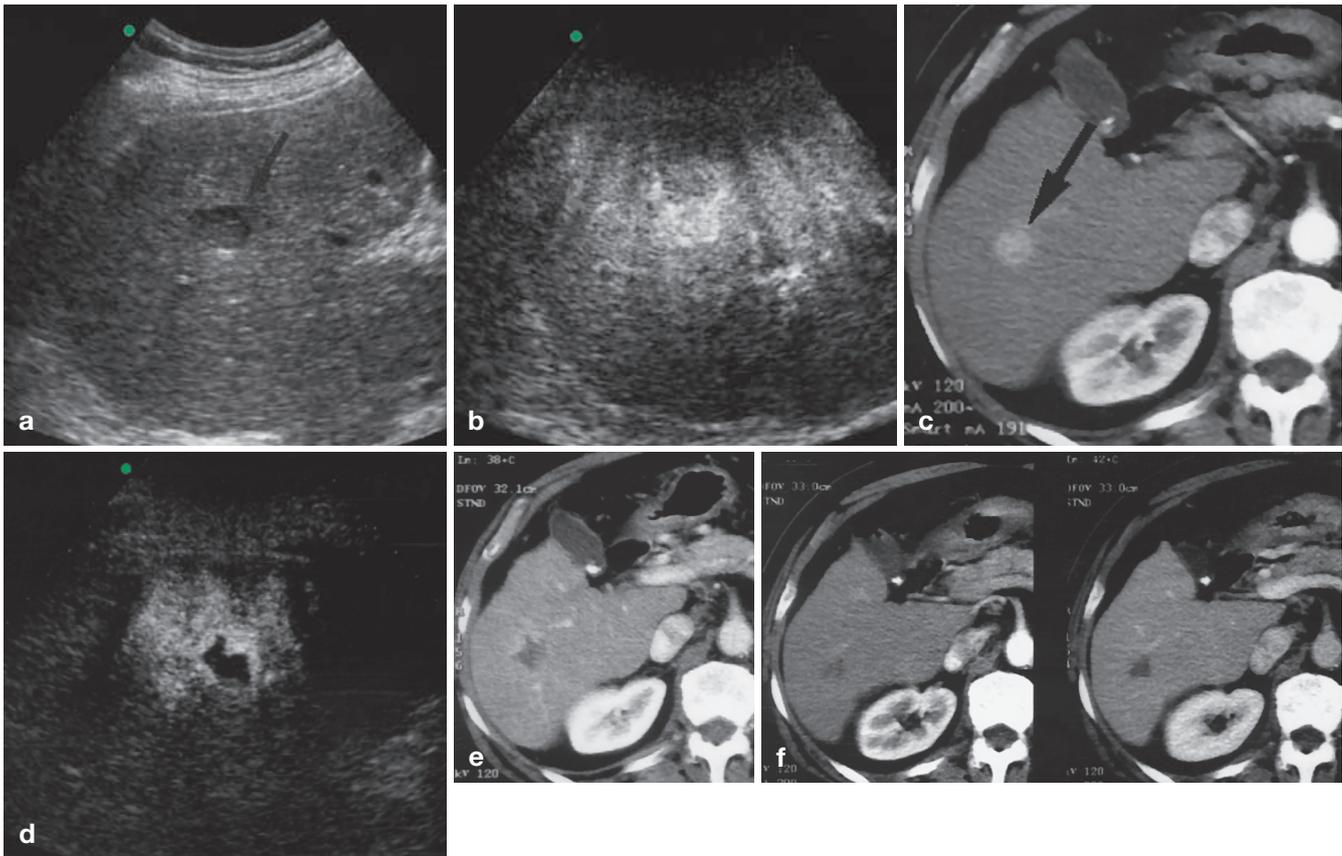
a–f Hepatocellular carcinoma treated with radio-frequency thermal ablation. Before treatment, the lesion (*arrow*) is detected as a hypoechoic nodule in a baseline US scan with marked homogeneous enhancement on the b arterial phase C-cube image. c Spiral CT confirms hypervascular tumor (*arrow*). d After the first radio-frequency treatment session, persistent peripheral enhancement is detected by C-cube image in the anterior aspect of the tumor. e Spiral-CT image confirms the presence of residual viable enhancing tumor tissue, matching the enhancing portions at contrast US. f After second treatment session performed with contrast US guidance, complete ablation is shown by dual-phase follow-up CT
